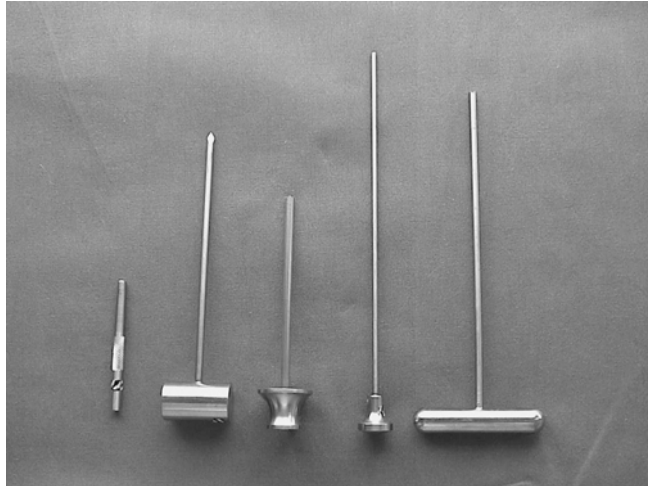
MRI compatible bone biopsy set.
